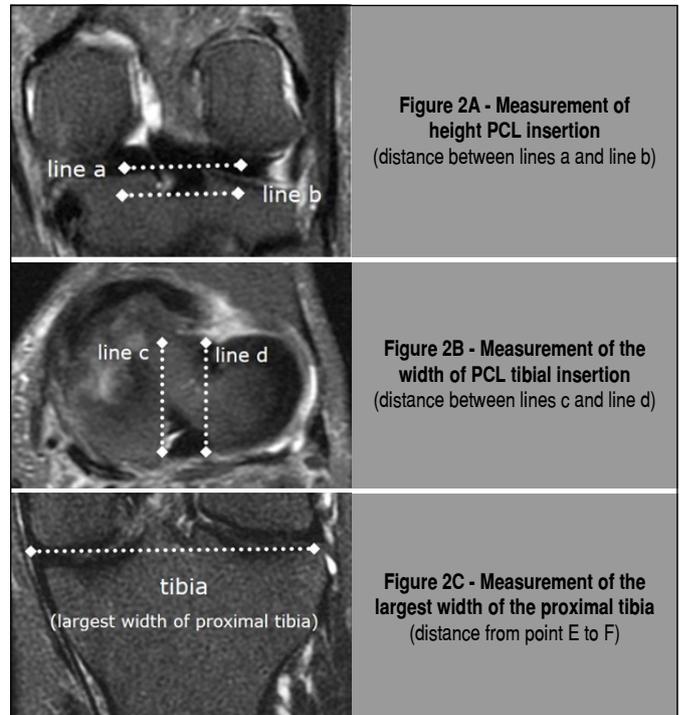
Measurements of height (2A), width (2B), and the largest width of the tibia (2C) performed on MRI scan.
